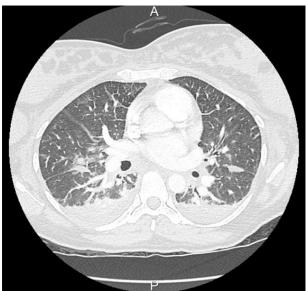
CT pulmonary angiogram with bilateral pleural effusions, ground-glass opacities and intraparenchymal nodules in the right lung.
